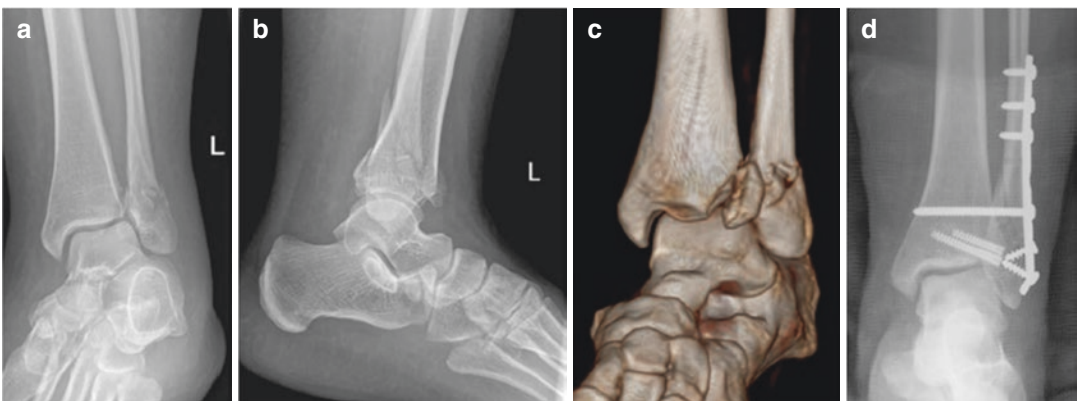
(a) AP X-ray of a Weber B distal fibular fracture in an athlete. (b) Lateral X-ray reveals the combined bony anterior syndesmotom fracture. (c) Coronal 3D CT
